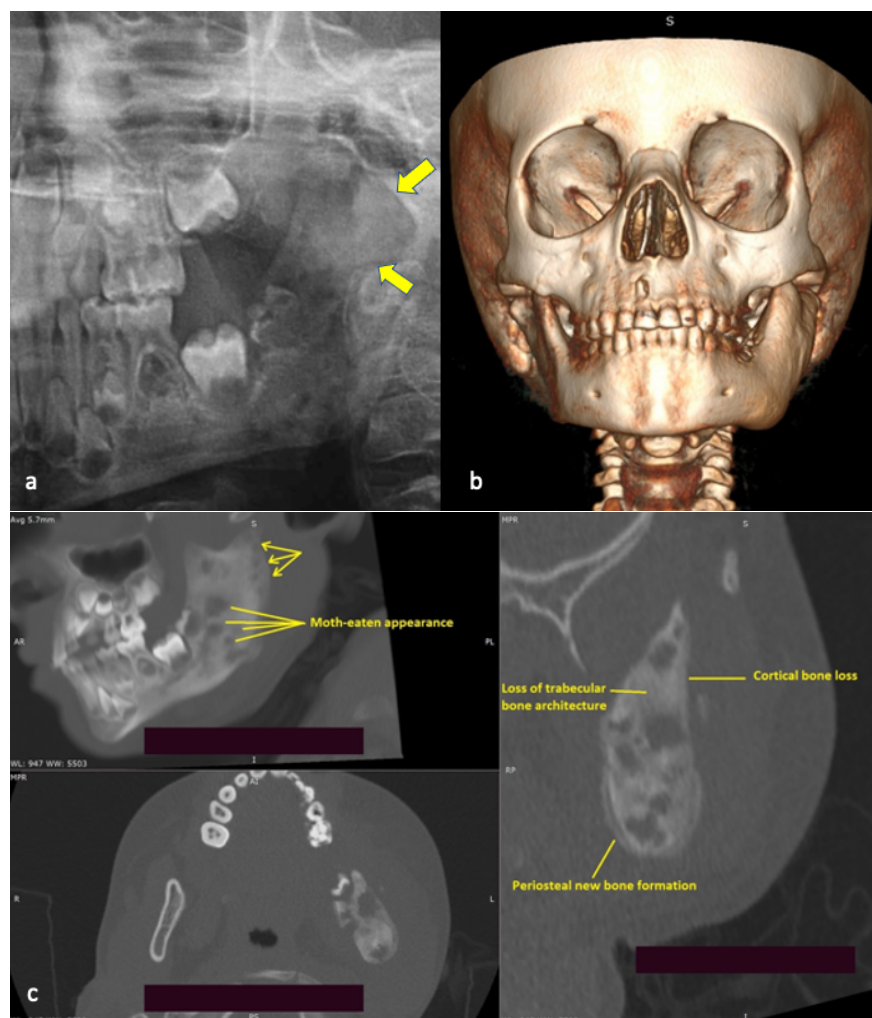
(a) Panorama radiograph :ill-defined lesion extending from the area of the developing mandibular left first permanent molar to the ramus, reaching the coronoid process. (b) The volumetrically rendered CT image showing left mandible enlargement. (c) Multiplanar views: sagittal, axial, and cross-sectional views with radiographic characteristics of osteomyelitis.
